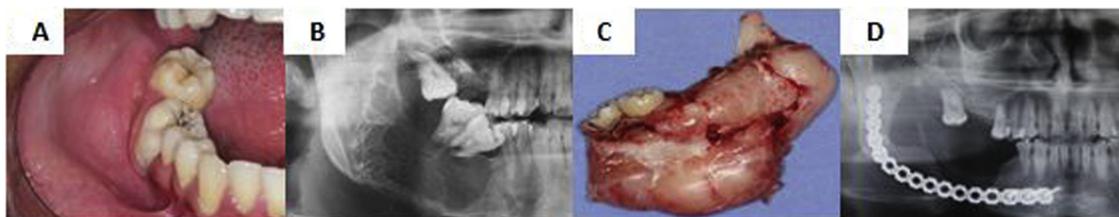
Case 1 general features. A: The patient presented a buccal swelling at the right mandibular ramus. B: Radiographic image revealed a hypodense, poorly delimited image at mandibular right posterior body and ramus. C: after OM final diagnosis, segmental resection was performed under general anesthesia. D: A reconstruction plate (2.4 mm) was used to restore the mandibular contour.
